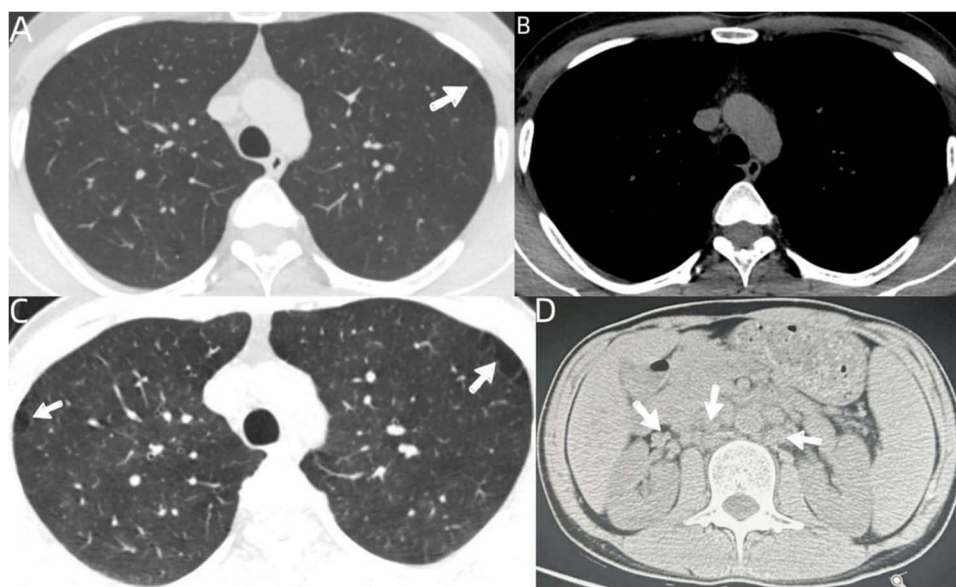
(A and B) Computed tomography scan showed multiple small nodular lesions in the upper lobe of the right lung and restrictive emphysema of both lungs in the lung and mediastinal windows on April 4, 2023 (white arrows); (C) Computed tomography scan showed new nodular lesions, and paraseptal emphysema in both upper lobes of both lungs in the lung windows on June 25, 2023, compared with the last chest CT examination (white arrows). (D) Abdominal CT scan showed multiple enlarged retroperitoneal lymph node lesions (white arrows).
